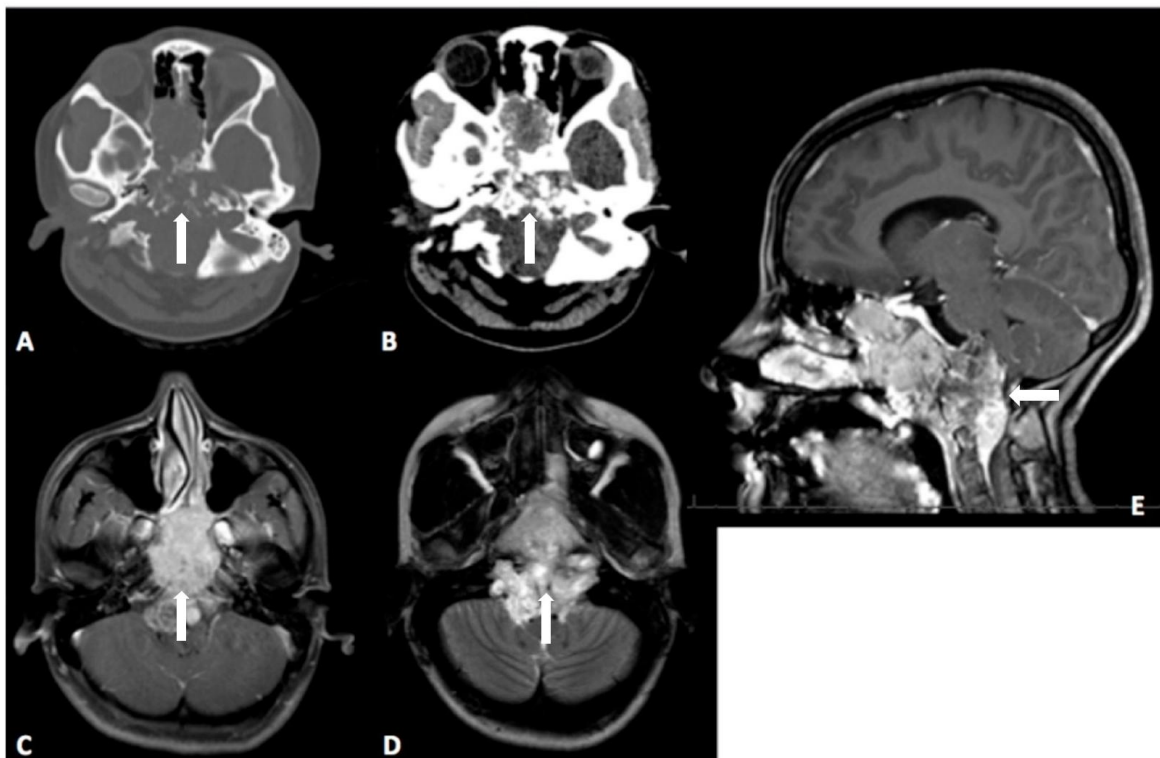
Imaging features of a clival chordoma. (A,B) Osteolytic lesion in the clivus. (C) MRI shows intense tumoral enhancement. (D) The clival lesion is hyperintense in T2. (E) Sagittal view: extension to inferior clivus, C1, C2, odontoid process, and rhino pharynx. White arrows indicate the anatomical region of the tumor located in the clivus. (Personal archive; patient informed consent was obtained). MRI, magnetic resonance imaging.
